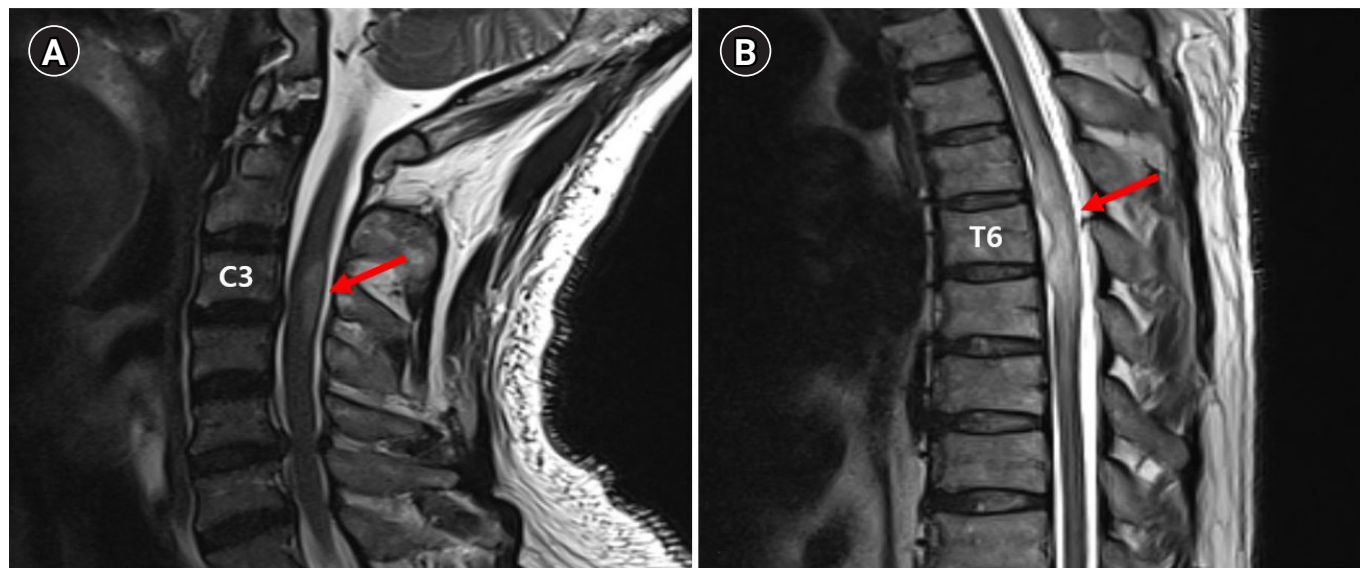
(A) Image showing high signal intensity between C3 and C4 level (arrow) at day 10 on T2 weight magnetic resonance imaging (MRI). (B) Image showing aggravation of lesion between T4 and T7 (arrow) at day 10 on T2 weighted MRI.
